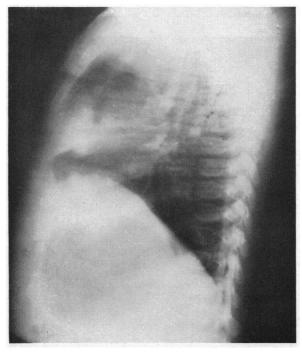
X-ray of child with cystic fibrosis that demonstrates earliest x-ray changes—increased radiolucency of lungs with bowing of sternum, increased AP diameter of chest, and right middle lobe pneumonia.
